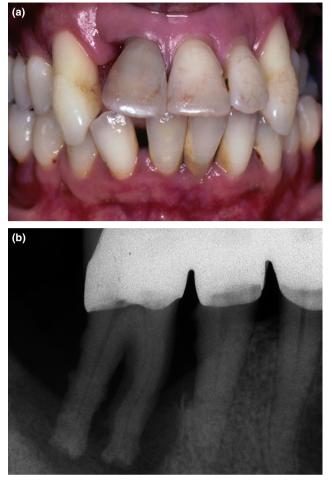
Severe periodontitis. (a) Uncontrolled periodontitis. (b) Severe bone loss about the mandibular right molar is evident in the radiograph
